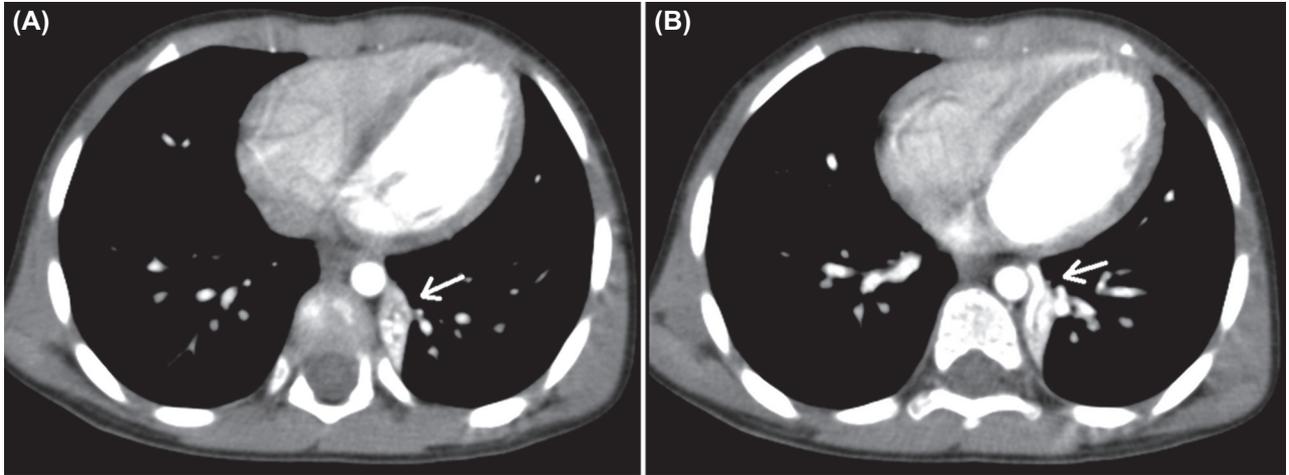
(A) Intralobar sequestration on CT (*arrow*) at the base of the left lung with (B) its blood supply from the abdominal aorta above the celiac tripod (*arrow*).
